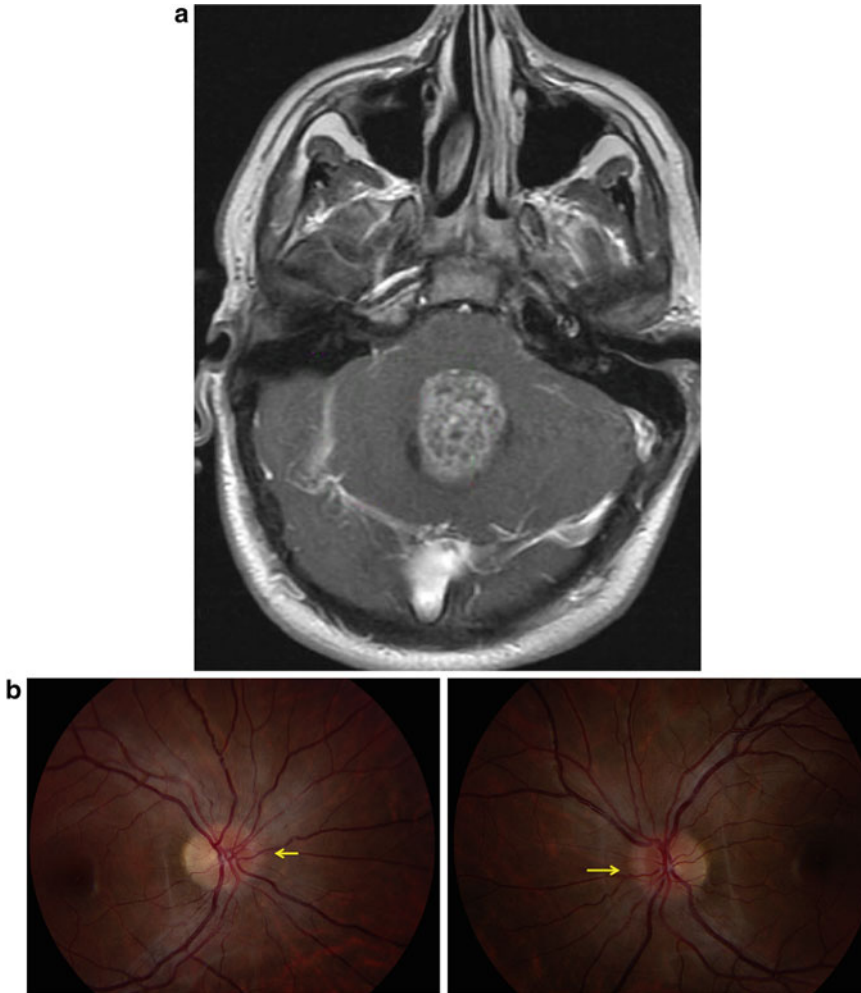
Posterior fossa astrocytoma. (a) T1 weighted MRI brain with and without gadolinium reveals a heterogeneously enhancing mass arising dorsal to the fourth ventricle, partially obliterating the fourth ventricle. The
